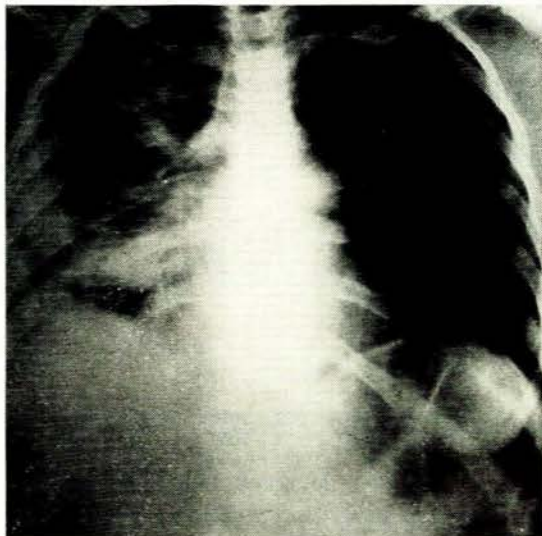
X-ray of the chest showing abscesses in the right upper, middle and lower lobes.
